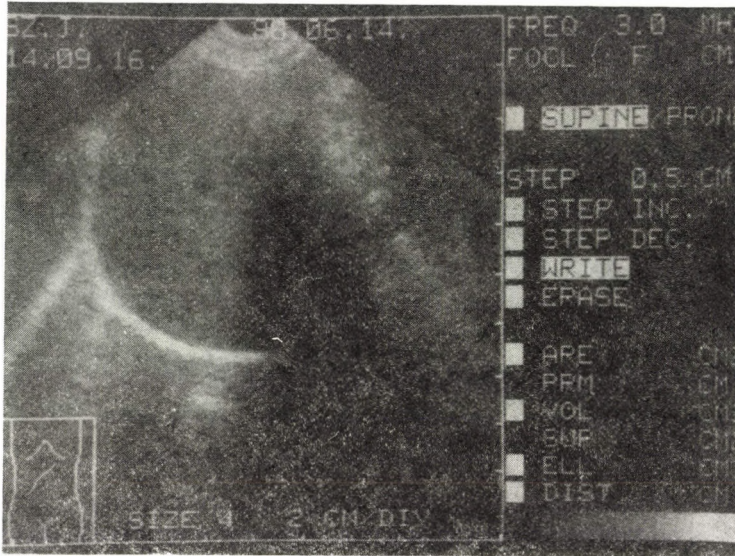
Sonogram (14, 06, 1988). The change earlier described in the hepar cannot be visualized. The more delicate gallbladder shows signs characteristic of cholelithiasis
